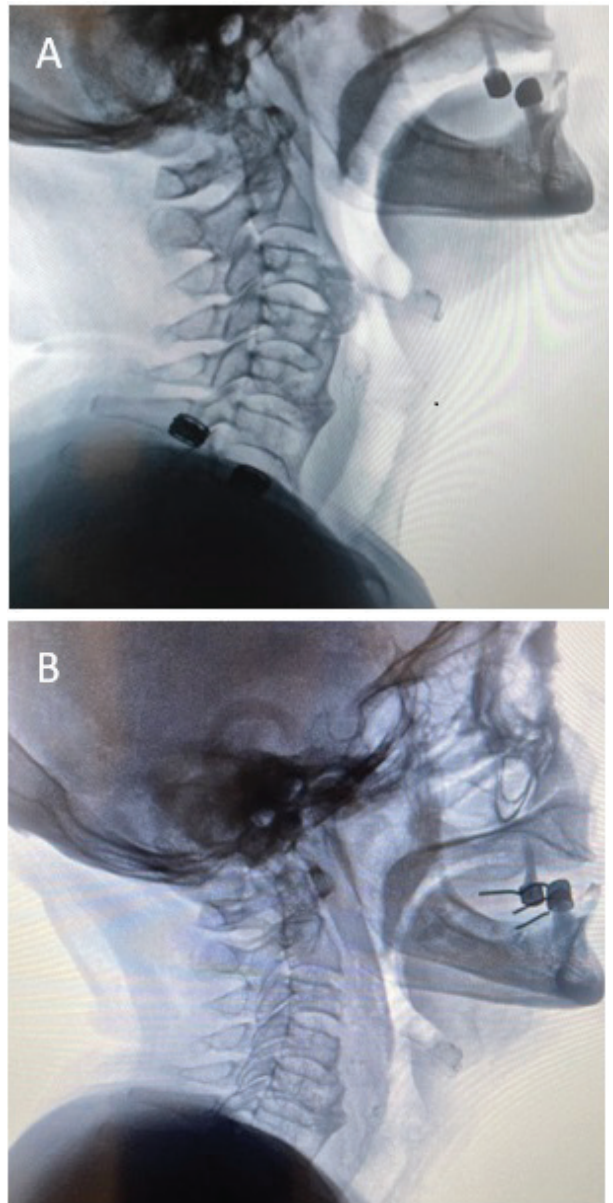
Lateral cervical X-ray of a patient with diffuse idiopathic skeletal hyperostosis (A). Same patient after undergoing anterolateral cervical osteophyte resection (B)
